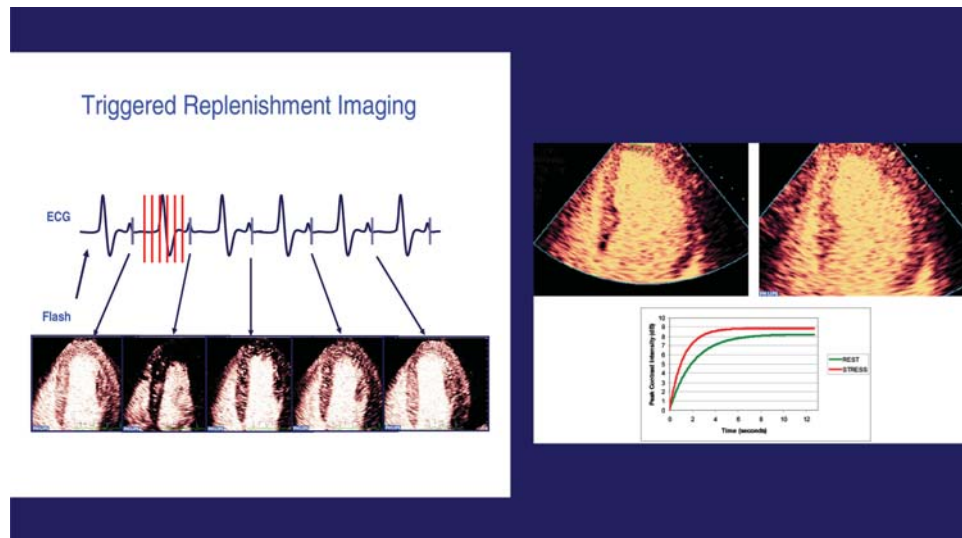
Quantification of myocardial blood flow by myocardial contrast echocardiography.
